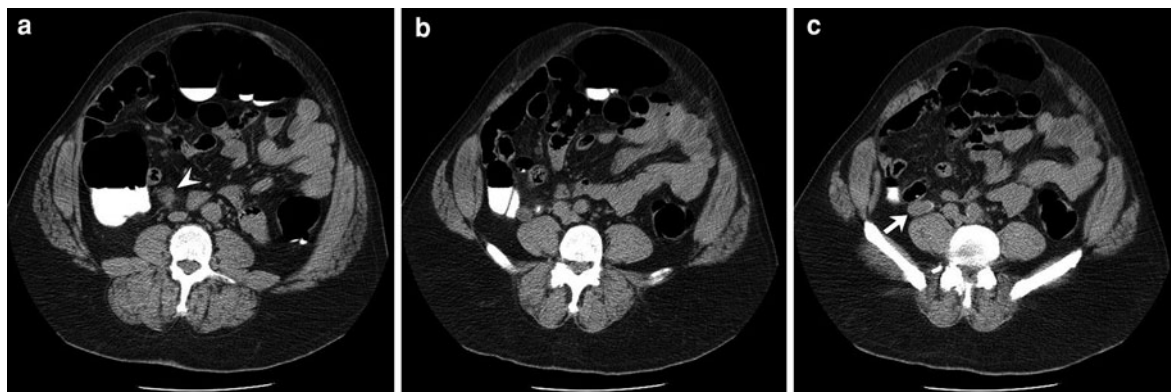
Asymptomatic colonic-type adenocarcinoma of the appendix detected at CT colonography screening. CT images from screening CT colonography show (a) ileocecal lymphadenopathy (arrowhead), (b) a patent contrast-filled proximal
